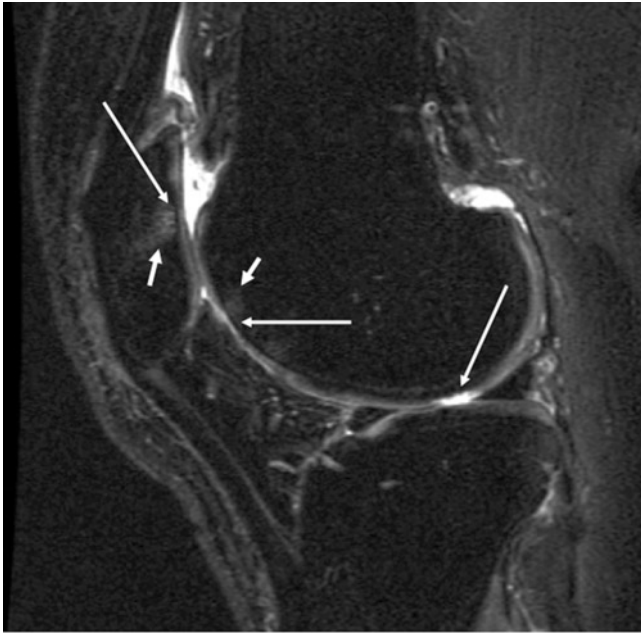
Sagittal fat-suppressed IM-weighted FSE (3,200/30 ms) MRI of the knee obtained in a 54-year-old woman with advanced degenerative disease of the femoropatellar joint. Note that cartilage lesions (*long arrows*), bone marrow edema pattern (*short arrows*) at the trochlea and patella, tendons, menisci, ligaments are well visualized with this fluid-sensitive sequence
